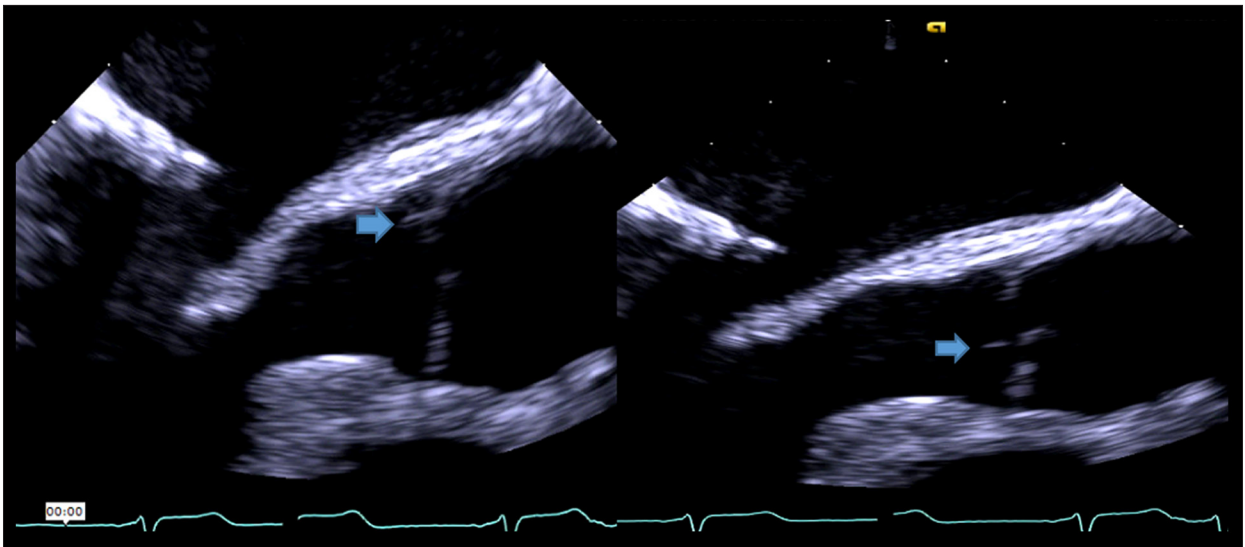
Transesophageal echocardiogram (TEE) showing multiple small, flickering masses post-Ross procedure on the aortic valve (native pulmonary valve) of a 43-year-old man with a history of systemic lupus erythematosus (SLE) who presented with endocarditis, which was later diagnosed to be an infection with *Coxiella burnetii*. The TEE was performed in 2019.
